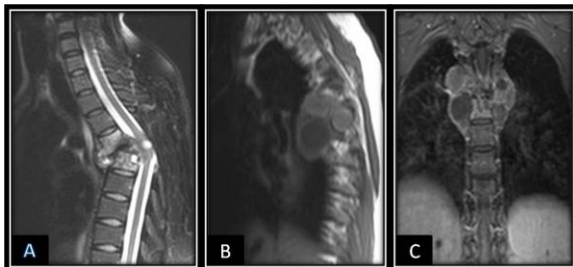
MRI Dorsal Spine (t1, t2 & t1 Post Contrast) Images Showing D4-5 Multiple Peripherally Enhancing Cystic Lesions with Small Cystic Lesion Causing Displacement of Spinal Cord
